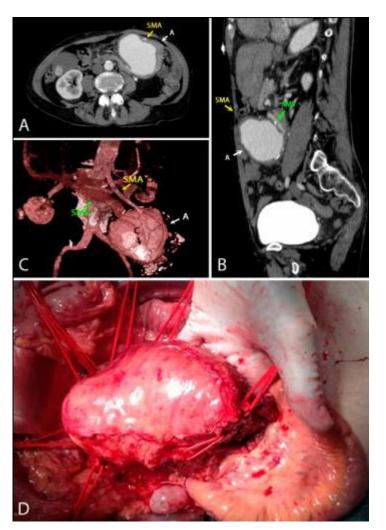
Management of visceral artery aneurysms. Non-invasive imaging techniques, in particular computed tomography angiogram scans were important for the diagnosis of a giant true aneurysm (A) arising from the distal branches of the superior mesenteric artery (SMA) and an arteriovenous fistula causing an enlargement of the superior mesenteric vein (SMV) (\mathbf{A} , \mathbf{B}). Further anatomical details were provided by a three-dimensional reconstruction, including the present of calcification (\mathbf{C}). Clamping of the aneurysmal sac for more than 30 min apparently excluded the presence of ischemic bowel (\mathbf{D}), a procedure that should be re-assessed according to the ulterior unsatisfactory outcome.
